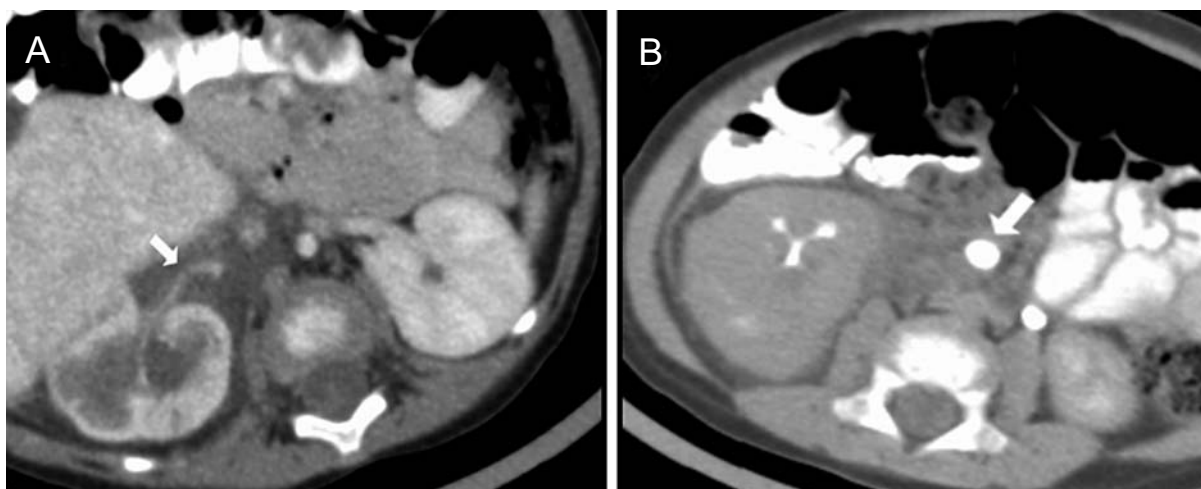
A) An infiltrative, hypodense lesion is identified in the renal sinus, parenchyma and perirenal space. The right renal artery is circumscribed by the lesion (arrow). B) Delayed CT image shows elongated and distorted collecting system by the renal sinus mass. The right ureter is enlarged and displaced medially (arrow).
